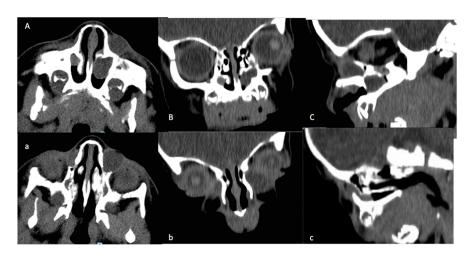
Axial (A, a), coronal (B,b) and sagittal (C,c) view CT scans showing the bilateral hourglass-shaped dacryocystocele.
